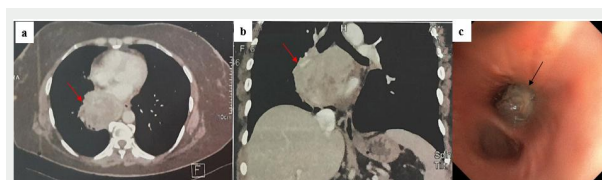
Axial (a) and coronal (b) slices in the mediastinal window with contrast enhancement of a thoracic computed tomography scan showing a tissue mass enhancing heterogeneously (red arrow), with its upper pole located in the subcarinal region. (c) Obstructive whitish bulge in the right lower lobar bronchus (black arrow) (endo-bronchial metastasis of renal cell carcinoma).
